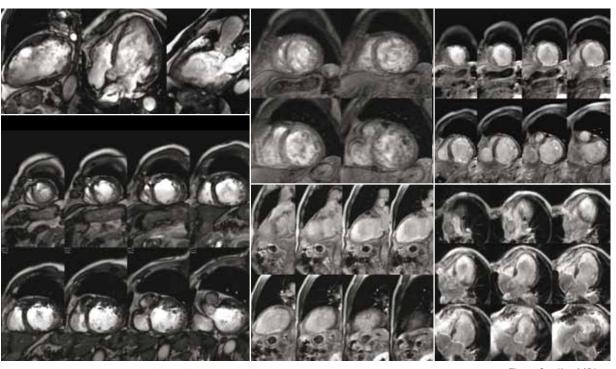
Cardiac MRI on a patient with elevated heart rate of 87bpm
